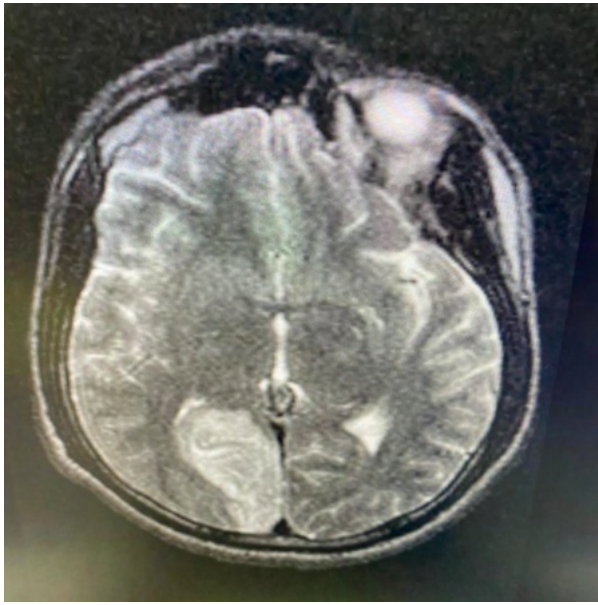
Magnetic resonance imaging showing ischemia in the right occipital region
